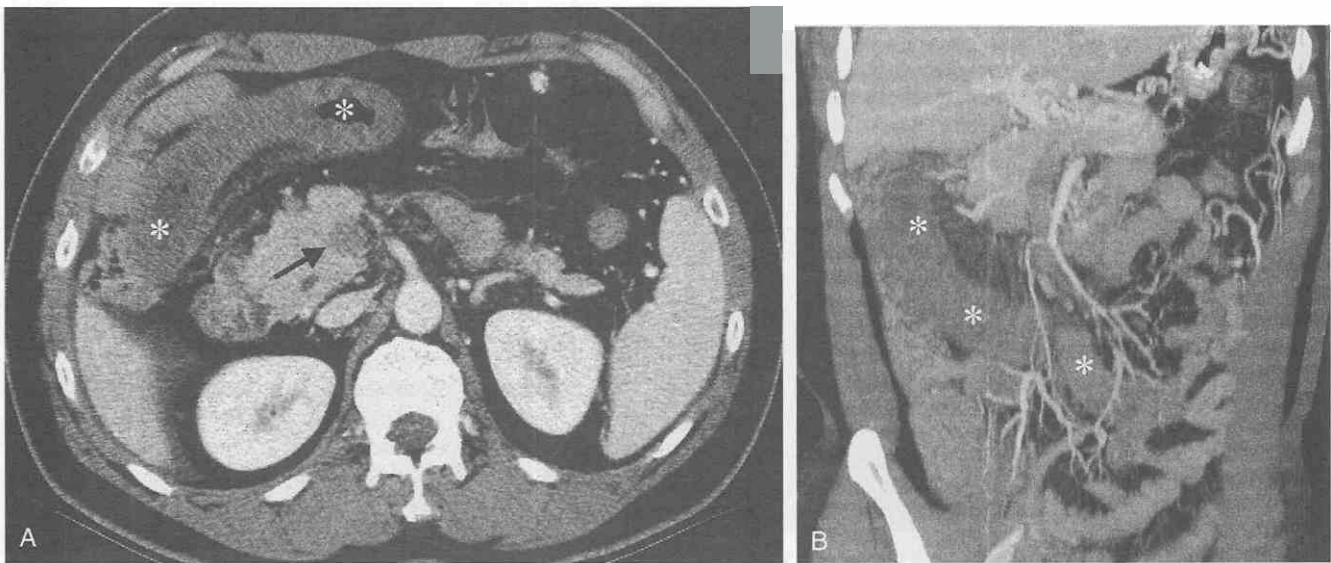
Intestinal ischemia resulting from mesenteric venous thrombosis. *A*, CT scan shows thrombus (arrow) in the superior mesenteric vein. Note diffuse bowel wall thickening (asterisks) of the small-bowel loop with poor contrast enhancement. *B*, Thick-slab (20-mm), coronal maximum intensity projection image shows favorable demonstration of the poorly enhancing ischemic intestinal segment (asterisks) as well as prominence of the regional vasa recta of the mesenteric vessels.
